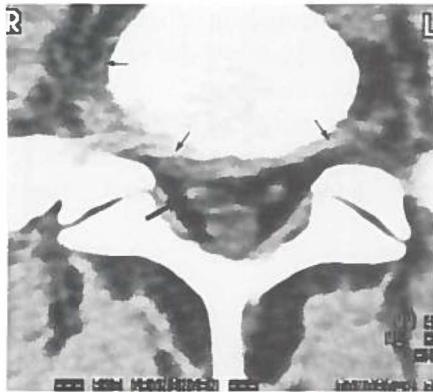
Case 4. CT scan at the same level three months after chemonucleolysis. No obvious hernia visible anymore and the position of the S1 nerve root is normal (arrow); slightly increased diffuse annular bulging can be demonstrated (small arrows). The gantry angulation of the CT scanner was slightly different from Fig. 3.19 due to the disc height reduction.
